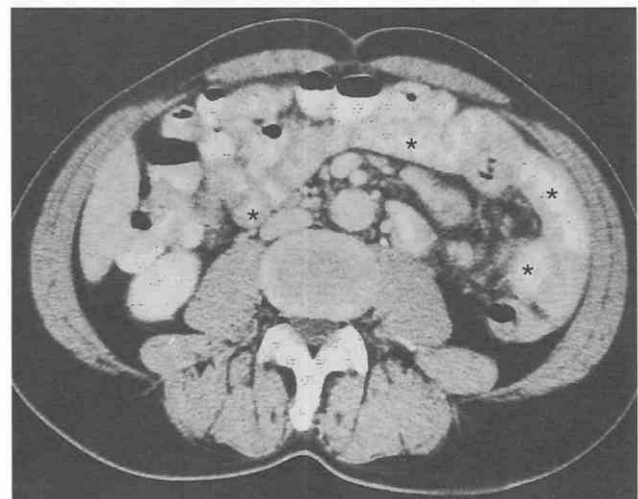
Crohn's disease. CT scan shows uneven, concentric bowel wall thickening (asterisks) of the small intestine.
